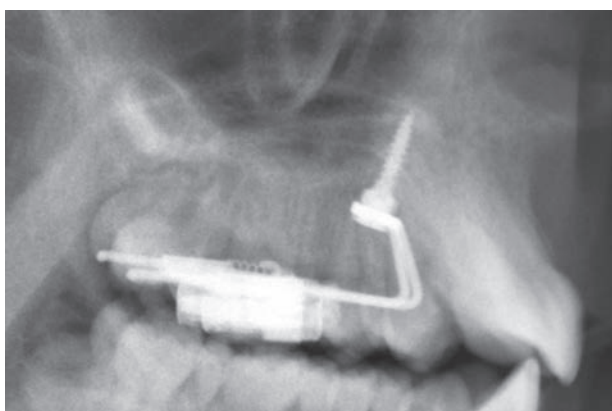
Lateral Radiograph Showing the Appropriate Insertion Site (Mini-implant Dimension: 2 × 9 mm).
